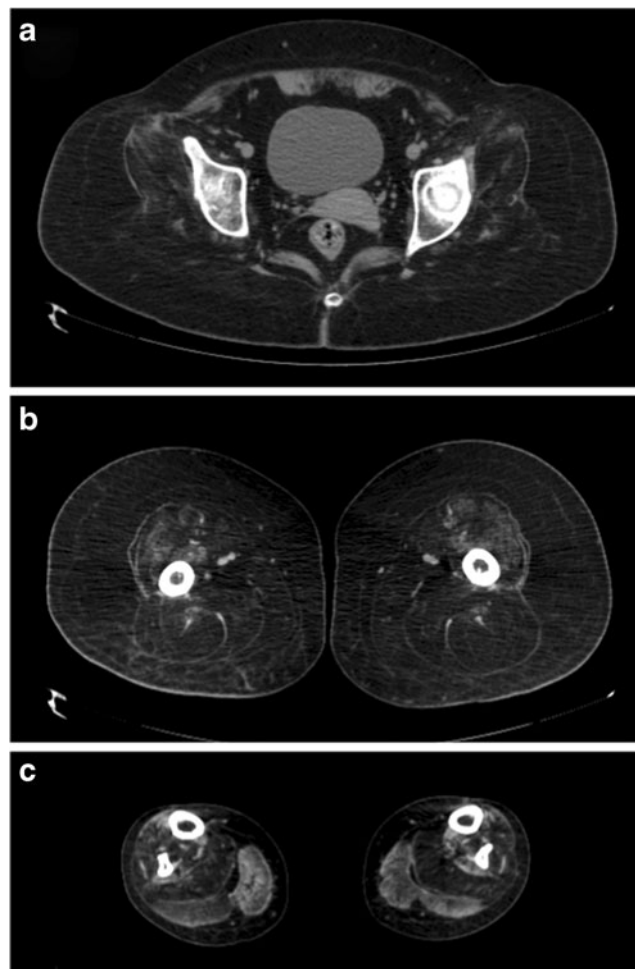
Computed tomography showing severe fat muscle substitution of the glutei (a); anterior, medial and posterior thigh (b); and soleus, fibularis, and moderate substitution of tibialis anterior and gastrocnemii (c)
